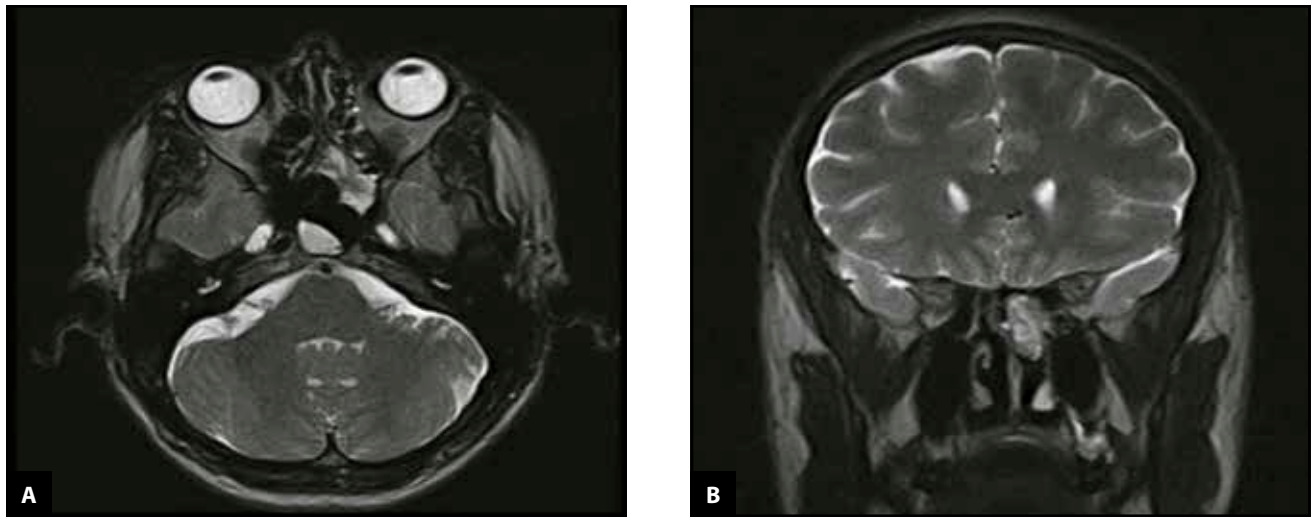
Craniofacial MRI, axial and coronal slices, showing a gadolinium-enhancing lesion in the left sphenothmoidal recess.
